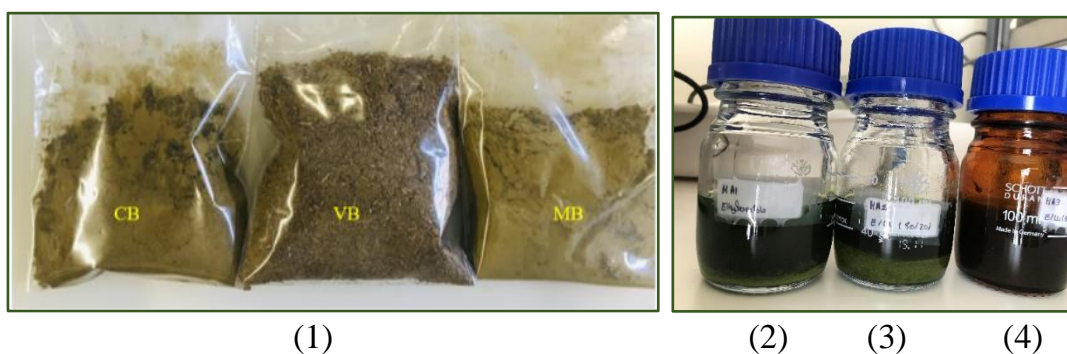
Photographic record of the ultrasonic extractions performed with olive leaves using three solvents: (1) Crushed dried leaves. (2) Extract obtained with ethyl acetate. (3) Extract obtained with ethanol/water (80:20). (4) Extract obtained with ethanol/water (50:50).
